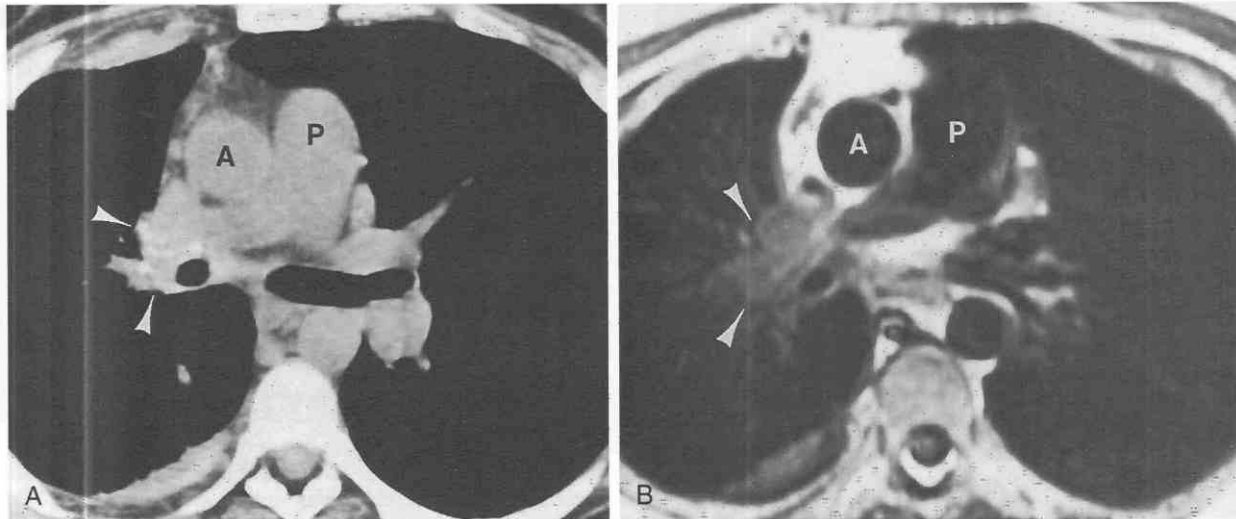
Fibrosing mediastinitis in a 45-year-old woman with chest pain. *A*, CT of the chest demonstrates an infiltrating right hilar mass (arrowheads) with punctate calcification and right posterior pleural thickening. *B*, Axial T1-weighted MR image shows intermediate-signal-intensity mass (arrowheads) and obstruction of the right pulmonary artery. The MRI appearance is nonspecific; the presence of extensive calcification on the CT scan suggests the diagnosis. A, ascending aorta; P, pulmonary artery. (Reprinted with permission from Erasmus JJ, McAdams HP, Donnelly LF, Spritzer CE: MR imaging of mediastinal masses. *Magn Reson Imaging Clin North Am* 8:59-89, 2000.)
